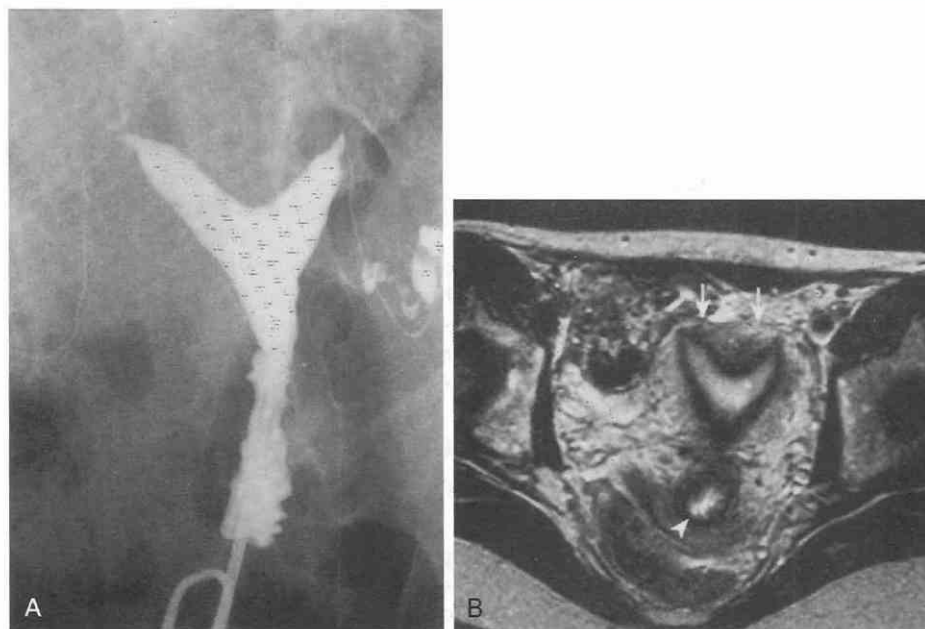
Septate uterus. *A*, Hysterosalpingogram in a 43-year-old patient with infertility. Bilateral tubal patency and uterine cornua with an angle of divergence of less than 90 degrees are seen. The appearance is consistent with bicornuate or septate uterus. *B*, T2-weighted fast spin-echo image in the axial plane (TR = 6200 msec, TE_{eff} = 102 msec) shows the divergent uterine cornua with a morphology similar to that seen in the hysterosalpingogram. The external surface of the uterine fundus is normal (arrows). Thus, a bicornuate uterus is not present, and this uterus has a shallow uterine septum. Arrowhead indicates the uterine cervix. TE_{eff}, effective echo time.
